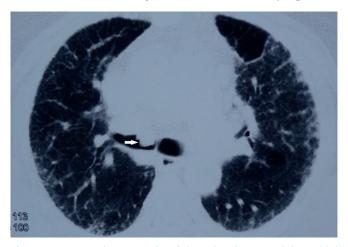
Computed tomography of chest showing an endobronchial tumour (white arrow) within the right main bronchus.
